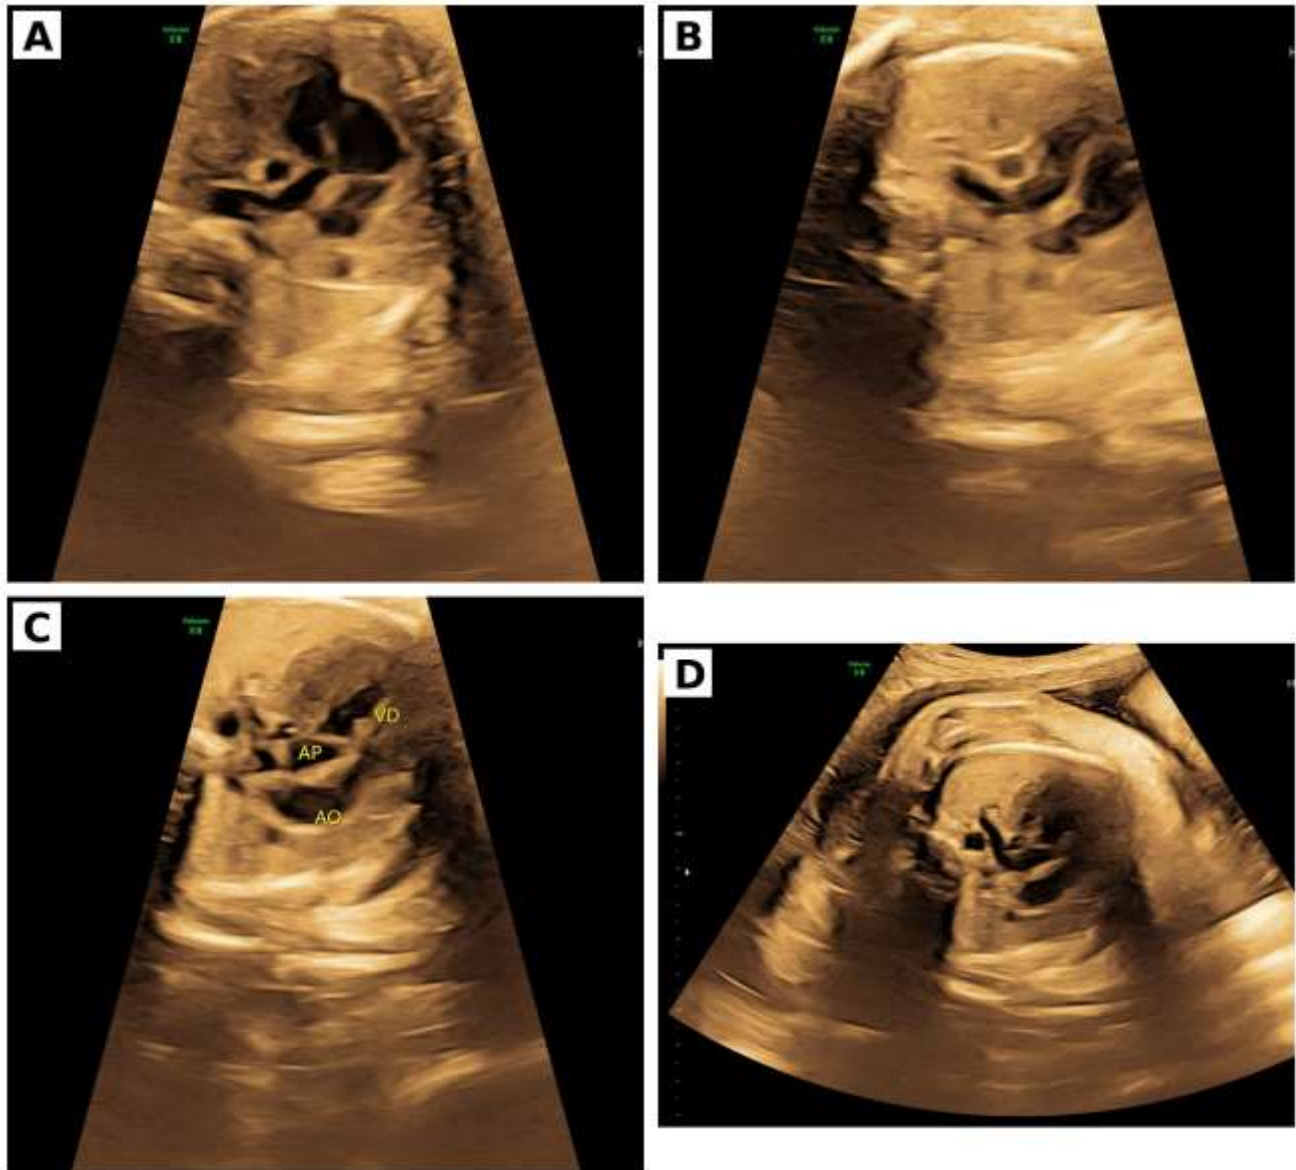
De-identified antenatal fetal cardiac ultrasound at 38 weeks and 3 days. (A, B) Four-chamber and transverse cardiac views showing ventricular imbalance and suspected ventricular septal defect. (C) Outflow-tract view showing the right ventricle (VD), aorta (AO), and pulmonary artery (AP) with abnormal spatial relationship. (D) Additional axial cardiac view supporting the diagnosis of a complex conotruncal anomaly. AP: pulmonary artery; AO: aorta; VD: right ventricle.
